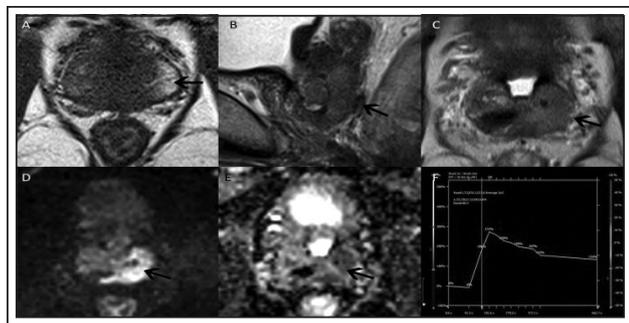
Example of a postbiopsy multiparametric MRI showing extracapsular extension.
